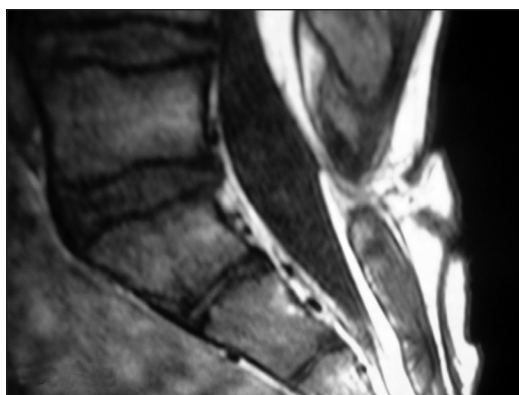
MRI lumbosacral region with spina bifida occulta associated with intradural and extraspinal lipoma
